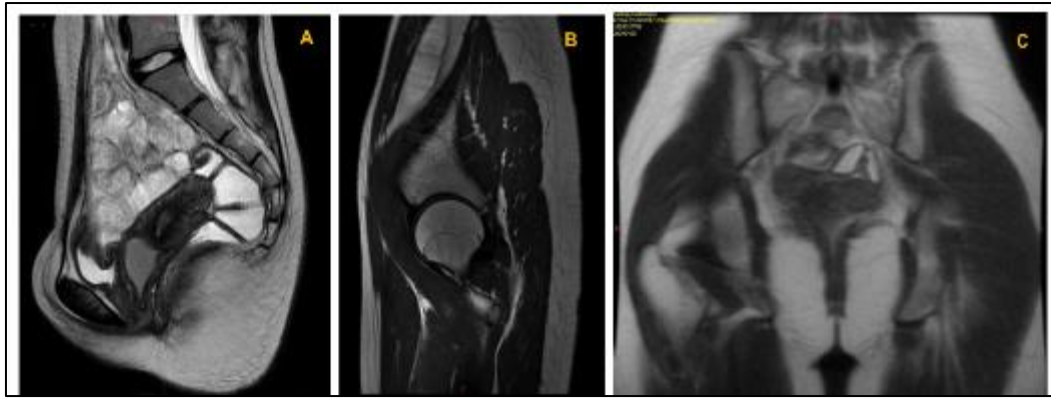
A; Contrasted MRI mid-sagittal view, right uterine cavity is visualized distended and B; contrast allows visualization of right hematocolpos, right side uterine cavity and right hemivagina are distended with a fluid of mixed intensity that is probably a blood component suggestive of right hematocolpometra. C; Normal left hemivagina
